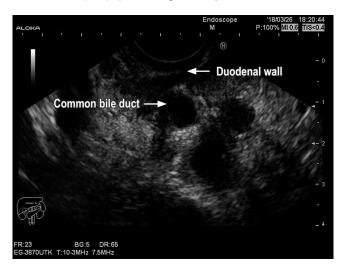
Endoscopic ultrasound image of edematous duodenal wall.
